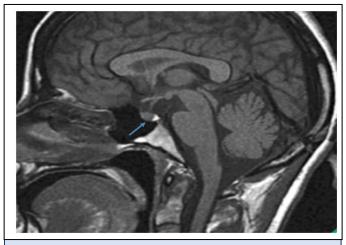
Pituitary MRI without anatomical changes (Blue arrow shows pituitary gland).
